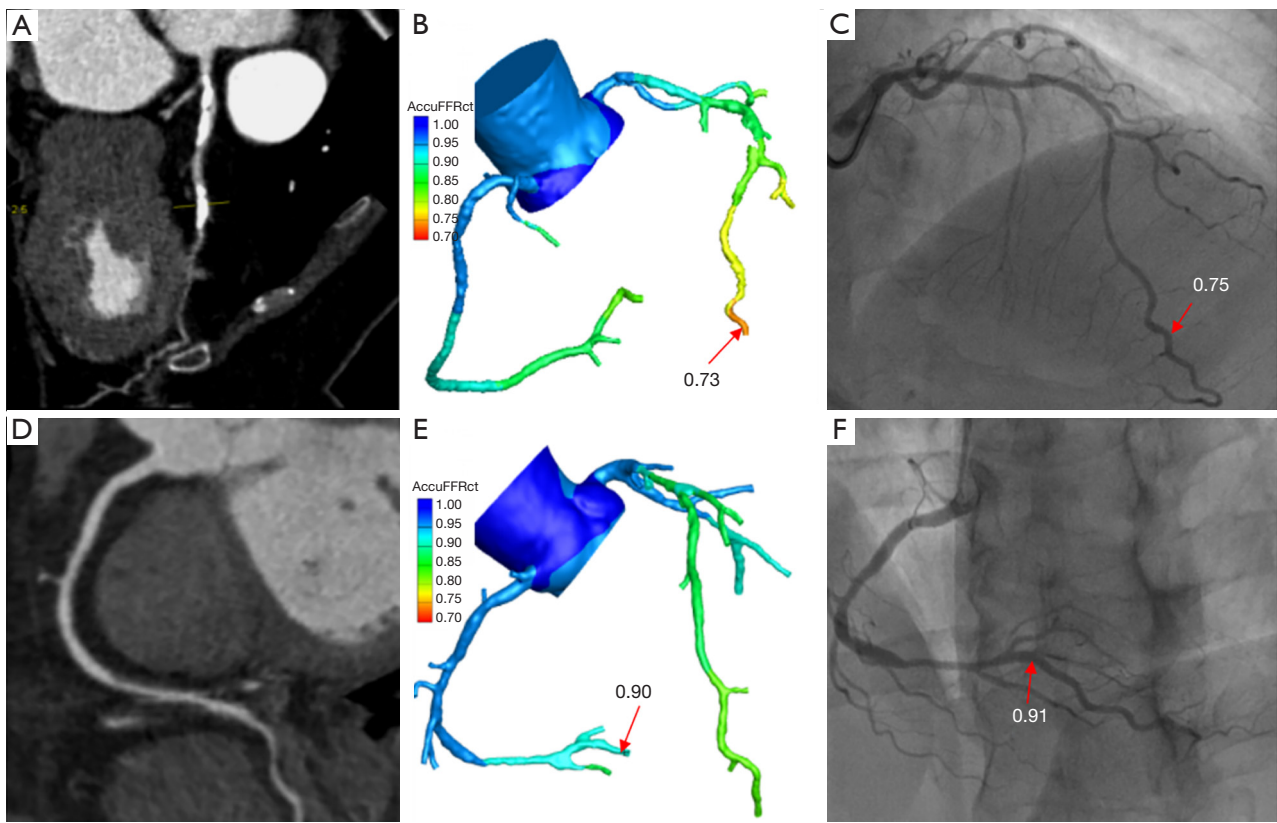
AccuFFRct results with invasive FFR measurement. (A) CCTA demonstrating 70% stenosis at the middle portion of LAD; (B) a computed AccuFFRct value of 0.73; (C) the corresponding measured FFR value of 0.75, demonstrating stenosis ischemia; (D) CCTA demonstrating 40% stenosis at the proximal-middle portion of RCA; (E) a computed AccuFFRct value of 0.90; (F) the corresponding measured FFR value of 0.91, indicating no stenosis ischemia. Red arrows indicate the position where FFR/AccuFFRct was measured. FFR, fractional flow reserve; CCTA, coronary computed tomography angiography; LAD, left anterior descending artery; RCA, right coronary artery.
